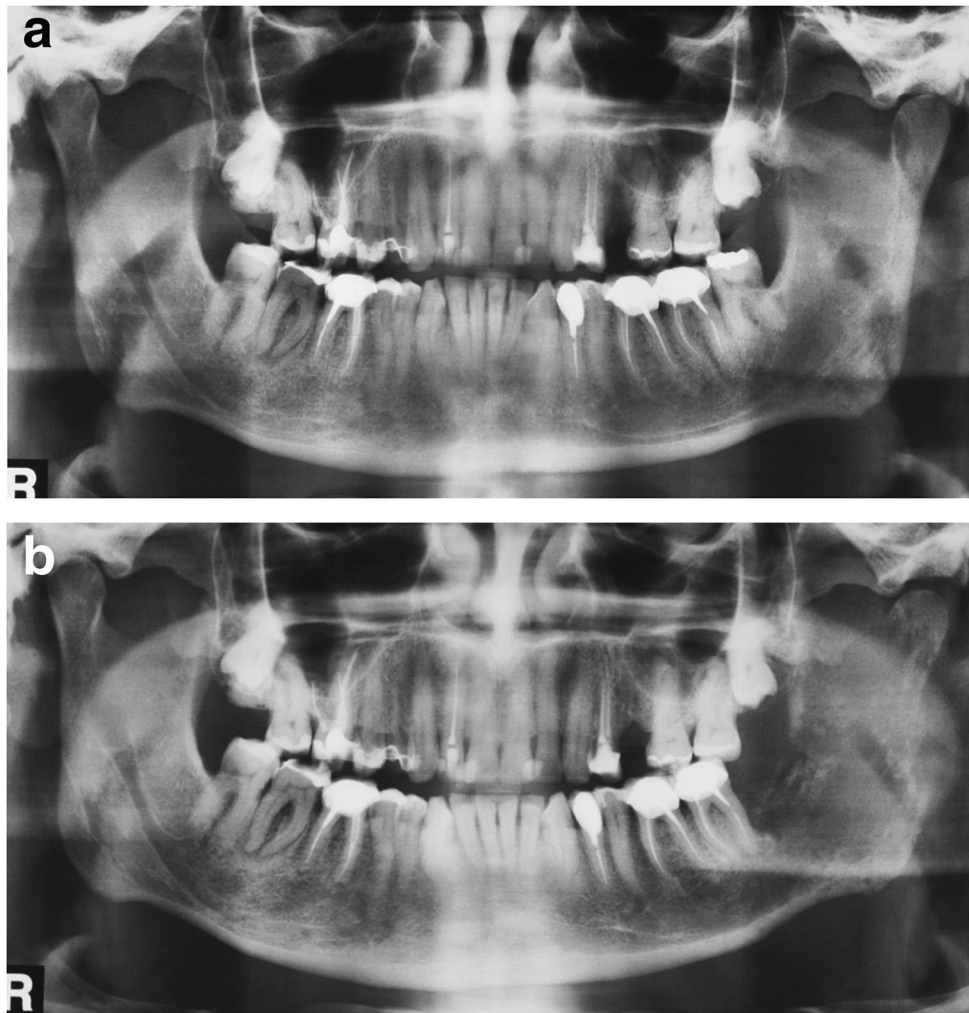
a Panoramic x-ray showing bone changes in the left ramus of the mandible. b Panoramic x-ray showing the fast evolution of the lesion with bone destruction of mandibular ramus
